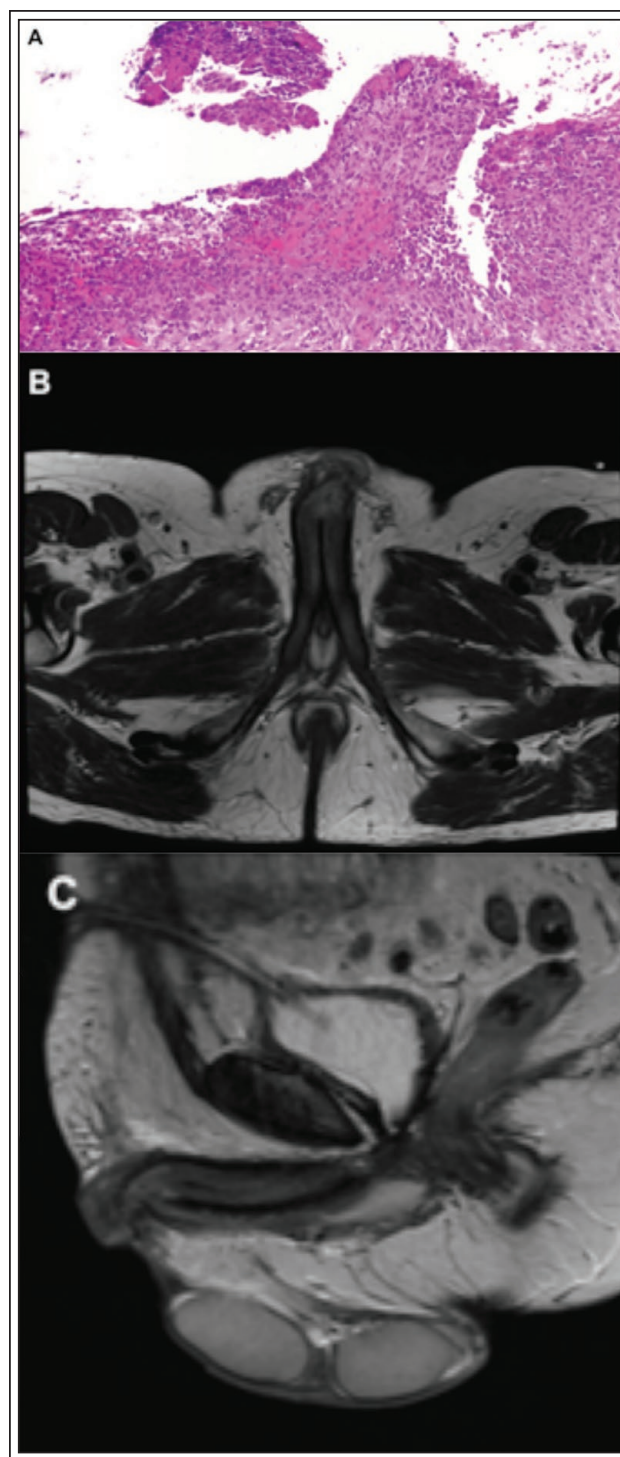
(A) Penile ulcer displaying chronic inflammation with underlying granulation tissue and no evidence of malignancy. (B) Axial and (C) sagittal MRI highlighting an enhancing lesion extending from the glans to include the distal shaft and corporal bodies with disruption of the tunica albuginea and fascial layers and without evidence of malignancy.
